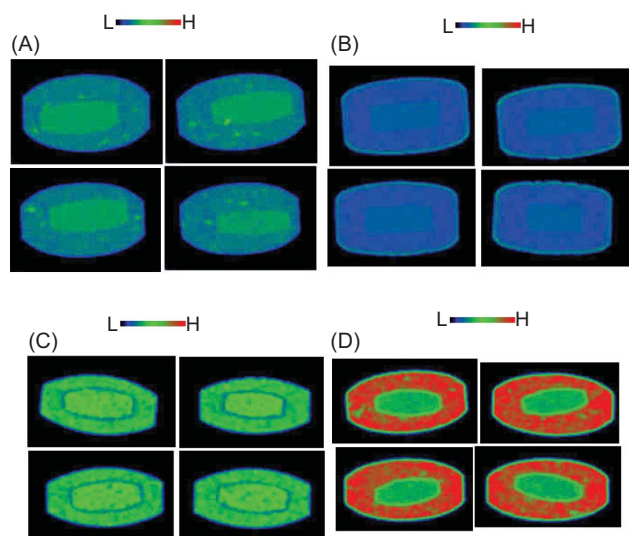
Imaging of commercial press-coated tablets from corporations A(A), B(B), C(C), and D(D) using X-ray CT.
